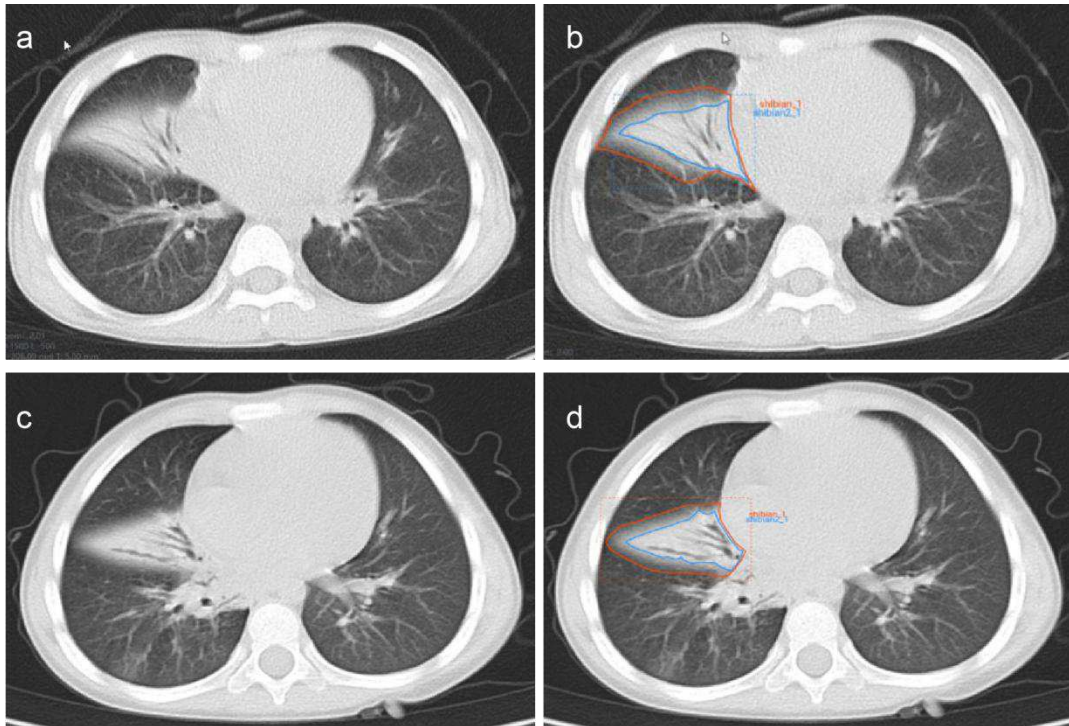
Manual delineation on lung window CT images in a 25-month female patient with mycoplasma pneumoniae pneumonia (Fig. 2.- a and b) and a 21-month male patient with streptococcus pneumoniae pneumonia (Fig. 2.- c and d). CT shows the similar appearances with consolidation and surrounding halo in middle lobe of right lung (a and c), and two ROIs (blue line and orange line) are delineated in each patient.
